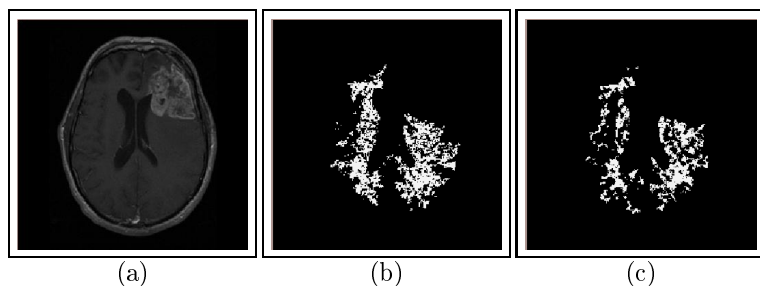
Slices of a (a) T1-weighted (with gadolinium) MR scene of the brain containing a tumor, and the corresponding largest (b) g - and (c) g_B -scale regions.
